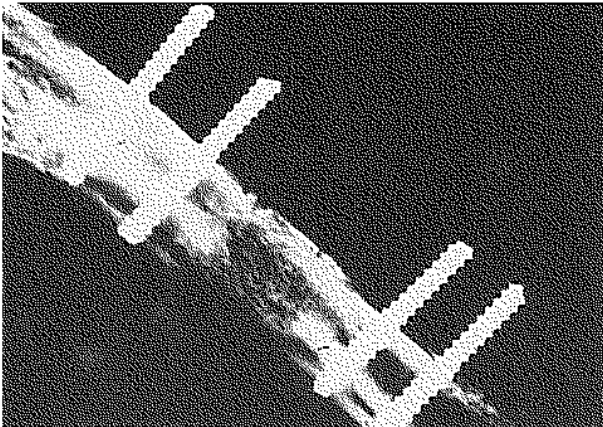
Radiographic bridging of the gap by new bone at 12 weeks in a defect filled with demineralized bone matrix.
